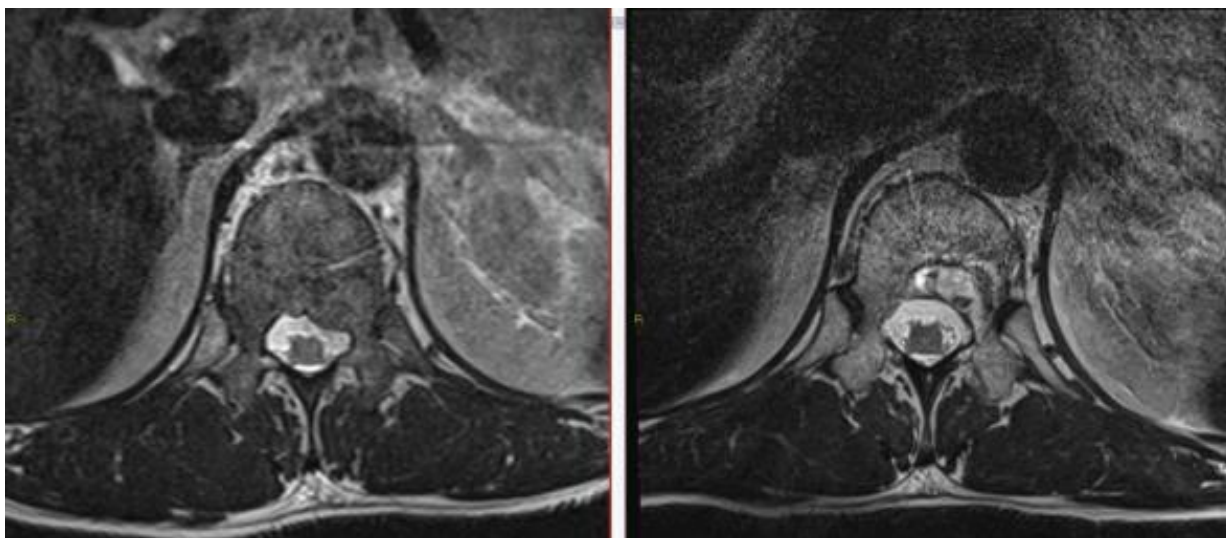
Serial T2 axial MRI showing oligometastatic disease to the posterior aspect of the T12 vertebral body pre-SABR (left) and 3 months post SABR (right). Note the normalisation of the spinal canal, and absence of persistent disease in the vertebral body, which correlated with a complete metabolic response on FDG-PET.
